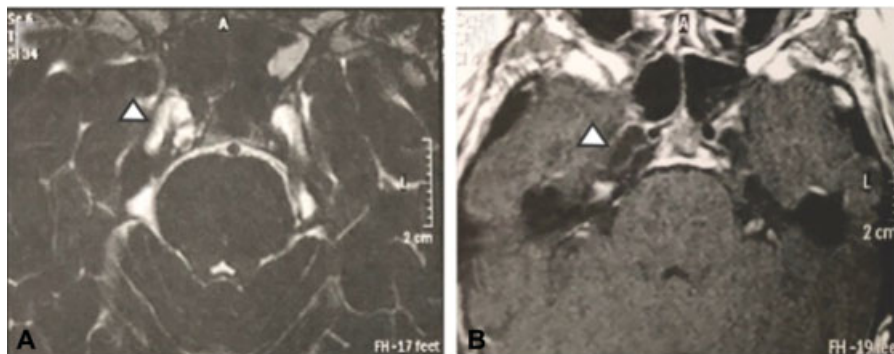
Meckel cave (MC) arachnoid cyst on magnetic resonance imaging (MRI). (A) T2-weighted MRI image showing right MC dilatation with cerebrospinal sign (arrow). (B) T1-weighted MRI image showing right MC dilatation (arrow).
